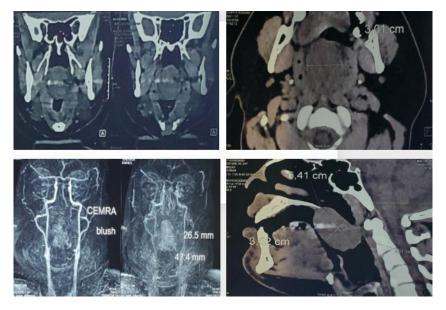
Cervico-facial CT scan in coronal, axial, sagittal section showing the soft palate hemangioma.
